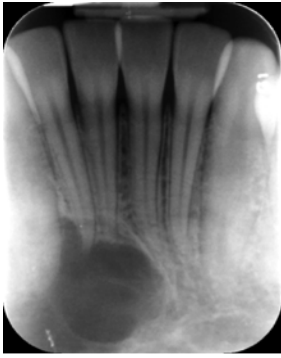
Periapical intraoral radiograph was taken in order to evaluate the periapical radiolucency in greater detail.
